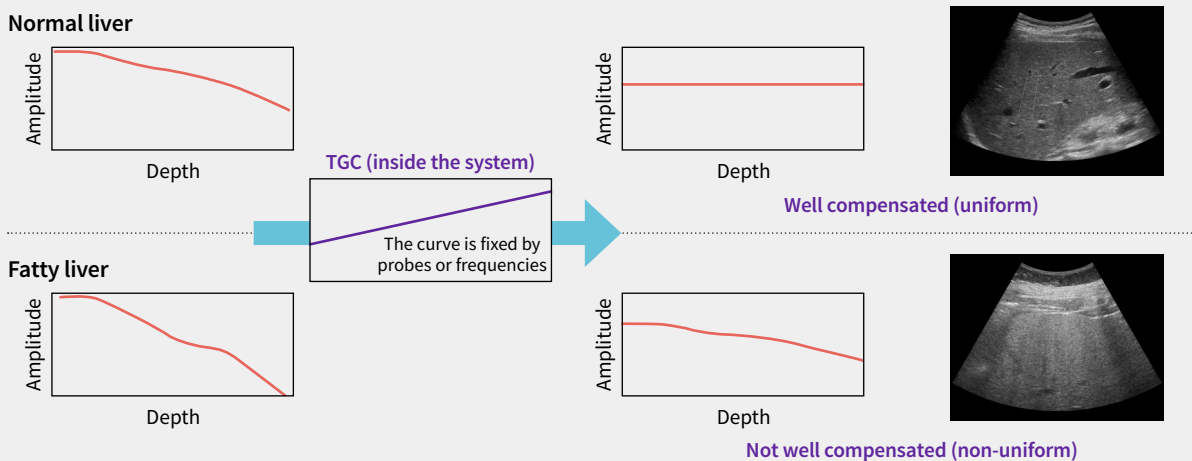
Ultrasound attenuation compensation by TGC.
